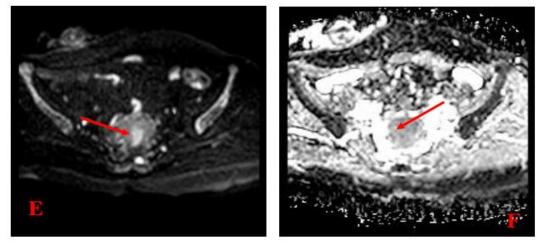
E- Axial DWI shows restricted pattern, F- ADC map shows low signal intensity with ADC value 0.85 x 10⁻³ mm²/sec.
